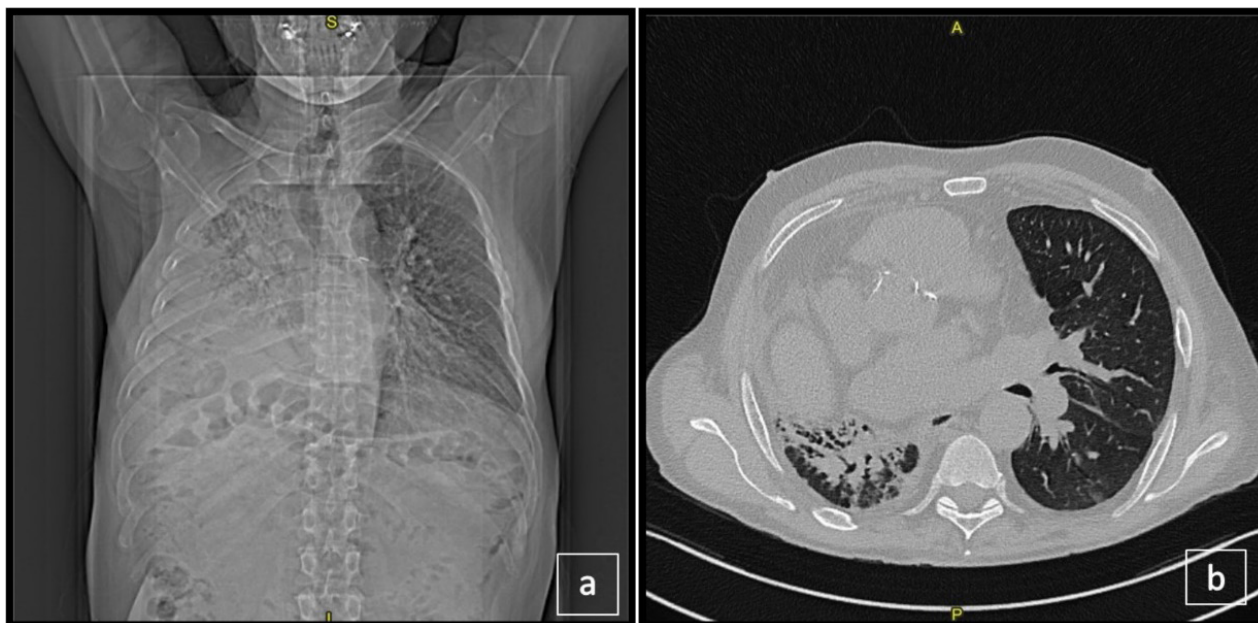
1A Preoperative chest X-Ray prior CT-scan, supine position. 1B Preoperative CT-scan, T6-T7 level. Right lung's interstitial fibrosis with cardio-mediastinal and hemidiaphragm retraction and left lung's fibrotic bands with cylindrical bronchiectasis are visible. ("S" Superior; "I" Inferior; "A" Anterior; "P" Posterior.)
